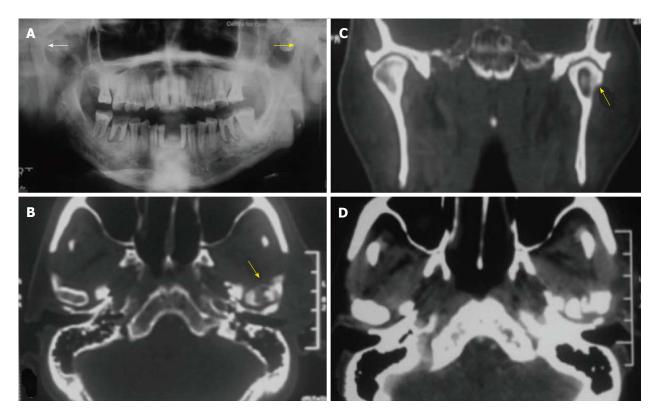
Chronic osteomyelitis of temporomandibular joint in a 55-year-old patient. Sclerosis of left mandibular condyle is seen in panorex radiograph (A); a bony sequestrum is seen within the left mandibular condyle in axial (B) and coronal (C) reformatted computed tomography (CT) images; axial CT section in soft tissue window (D) shows inflammatory changes in tissues around the temporomandibular joint.
